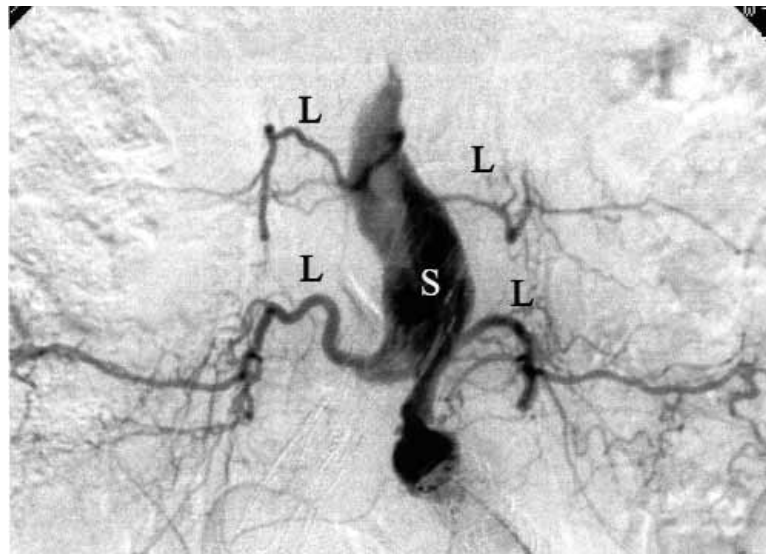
Intra-aneurysm sac injection after endovascular repair of AAA (*L*). Contrast injection through a 5F intrasac catheter 30 hours after uniliac stent graft repair of AAA shows multiple patent lumbar arteries. Systemic pressure was measured from within the sac (*S*). The patient had a negative result from CT scan 30 minutes before angiogram.
